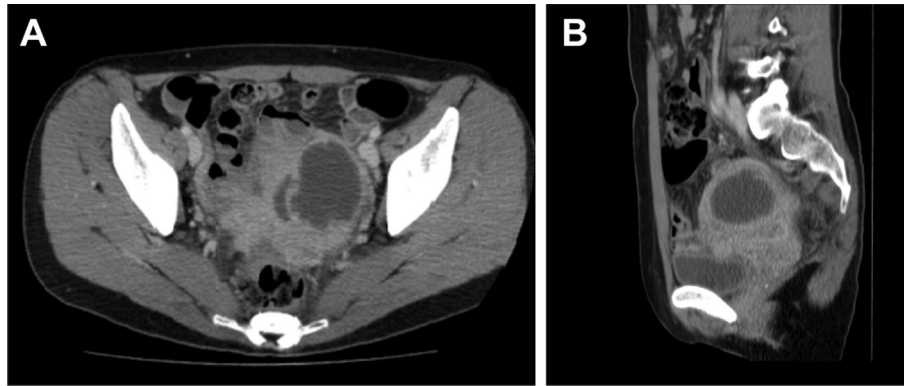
Abdominal contrast CT examination. (A) Transverse cross-section. A tumor with contrast effect accompanied by a low-density area was noted in the left pelvis. (B) Sagittal cross-section.
